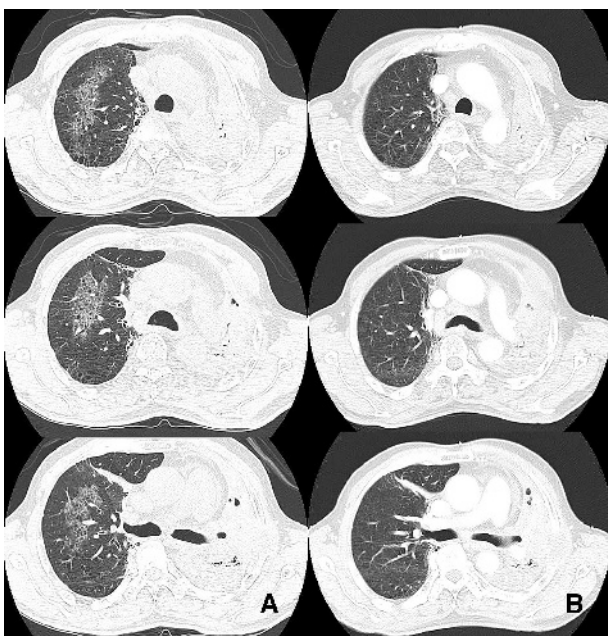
Interstitial pneumonia in a patient receiving gefitinib. The chest CT scan (A) showed ground-glass attenuations. Gefitinib was discontinued and empirical therapy with prednisolone and clarithromycin was started. After 2 weeks, the chest CT scan (B) showed resolution of the interstitial pneumonia.
